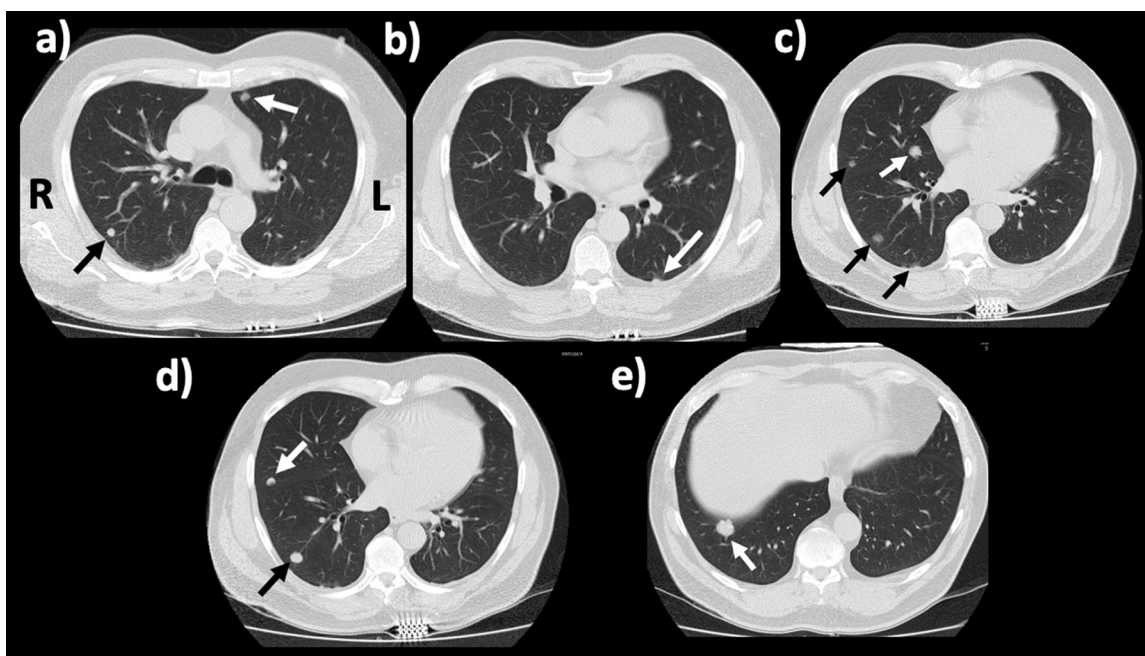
CT guided tissue ablation performed on June 23, 2017. (A-E) Multiple lung lesions, from superior to inferior. A total of 8 metastases were targeted by microwave ablation using a 20-cm 14-gauge Covidien system.
